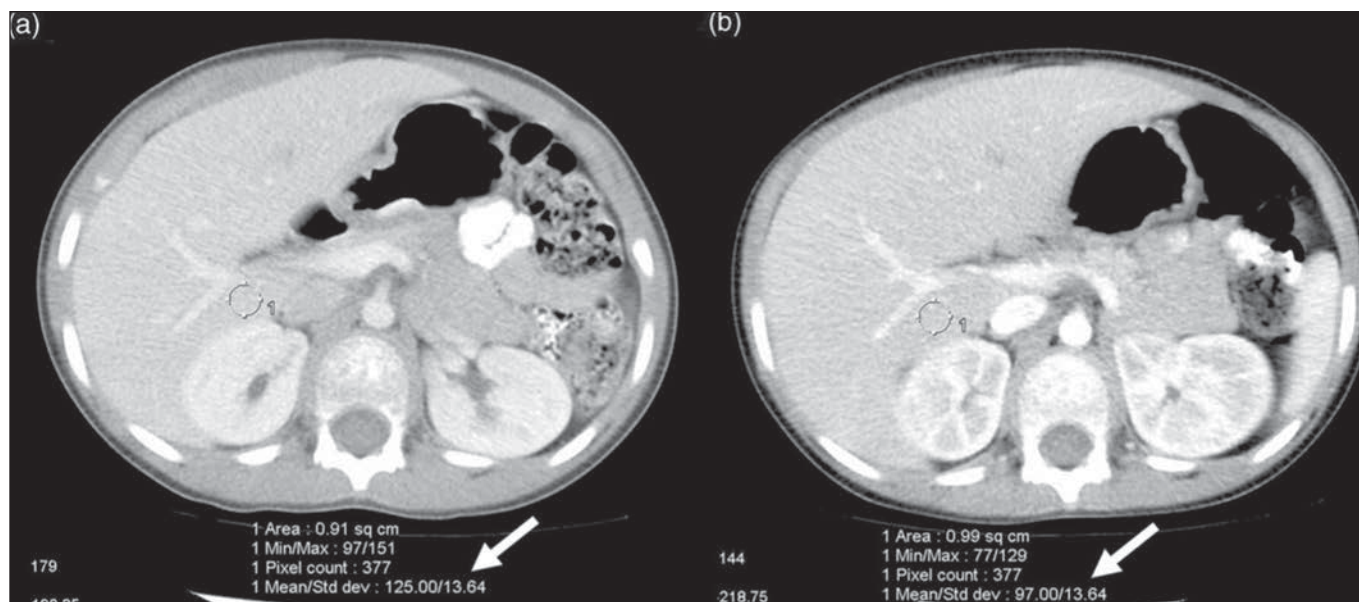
Patient weighing 23 kg underwent two CT examinations performed approximately 30 days apart. Both images show same SD of attenuation of 13.64 HU (arrow) in 1-cm² ROI (circle labeled “1”) posterior to right portal vein. Min = minimum, max = maximum, Std dev = SD. (Used with permission of John Wiley & Sons—Books, from Characterization of adaptive statistical iterative reconstruction algorithm for dose reduction in CT: pediatric oncology perspective, Brady SL, Yee BS, Kaufman RA, *Med Phys*, 39, 2012; permission conveyed through Copyright Clearance Center, Inc.)
